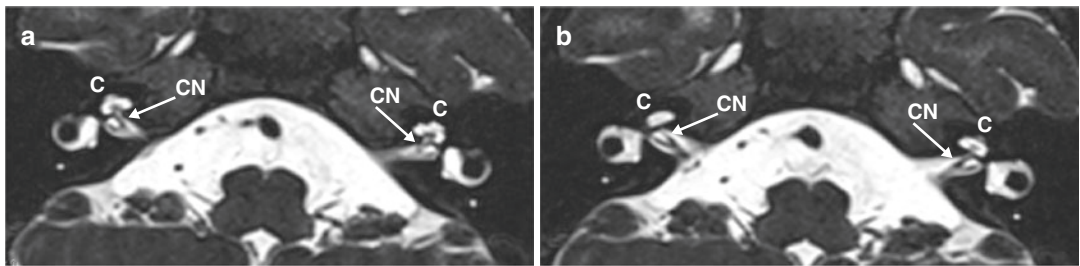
Magnetic resonance imaging showing normally developed cochlear nerves (CN) on both sides (a and b)
